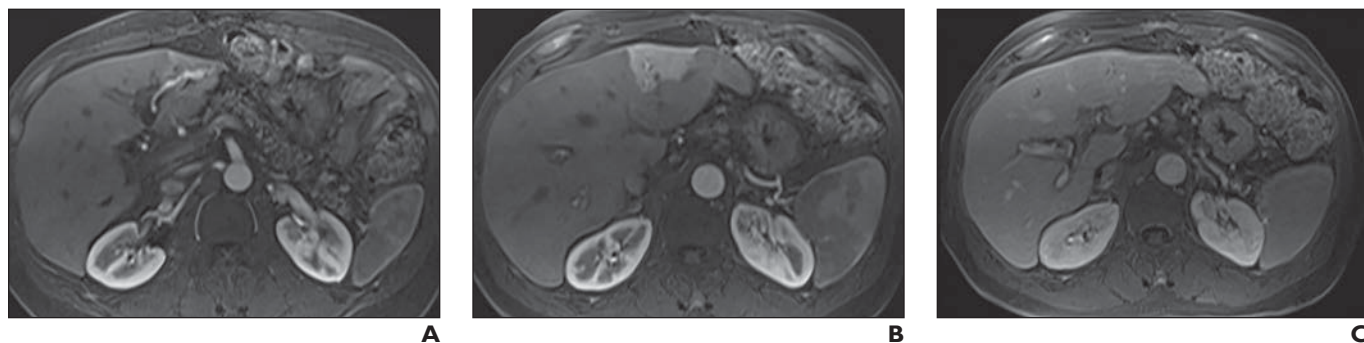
59-year-old man with small arteriovenous fistula and previous biopsy. Example of vascular abnormalities. Triangular area of arterial phase hyperenhancement (transient hepatic intensity difference) in segment II equilibrates in portal venous phase. In segment II–III, small focal area of dilated anomalous connection between hepatic artery and portal vein represents small arteriovenous fistula. Patient had undergone ultrasound-guided liver biopsy in vicinity 2 months earlier.
